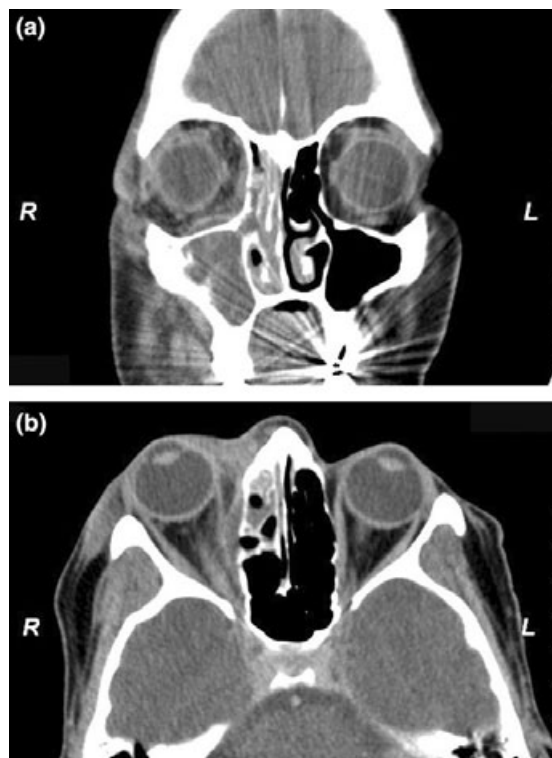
Computed tomography-scan in frontal (a) and axial (b) view. Besides complete obturation of the maxillary sinus, the frontal view (a) demonstrates a convex elevation of the periorbital membrane because of the subperiosteal abscess formation. In the axial view (b) a similar involvement of the orbit is seen at the medial orbital wall in close proximity to the partially obturated ethmoid cells. The medial rectus muscle is displaced laterally. In this section the significant protrusion of the globe becomes obvious.
